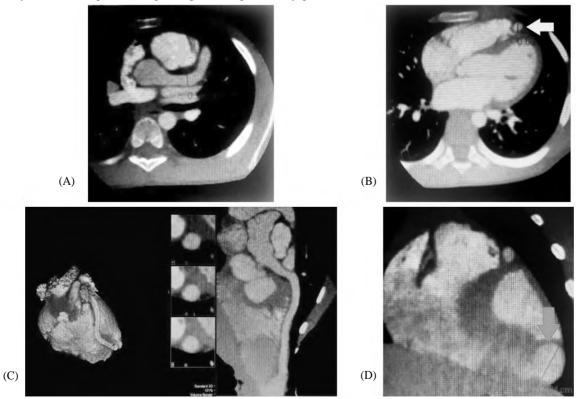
(A,B) Axial CT images showing dilated LCA (red arrow) and LAD (white arrow). (C) 3D volume-rendering and oblique MPR images displaying dilated tortuous LAD ending by forming large aneurysm measuring about (30 x 20 mm) at maximal dimensions, as shown in (D) which shows LAD joining the right ventricular apex via an abnormal fistulous communication measuring about (9 mm) in width, thus creating left-to-right shunting of blood.
